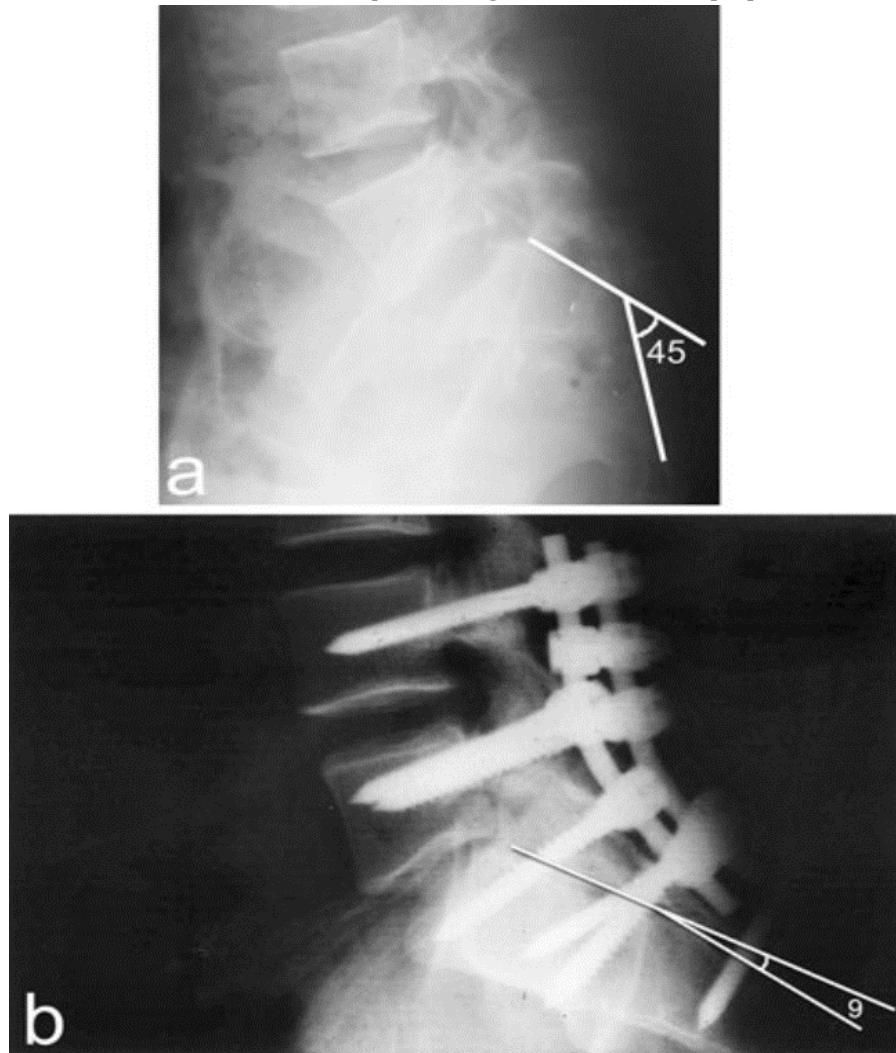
A preoperative lateral radiograph shows 45 dg _ initial transverse sacral fracture kyphosis angle. B The same radiograph at final follow up with improvement of the angle down to 9 [22].
